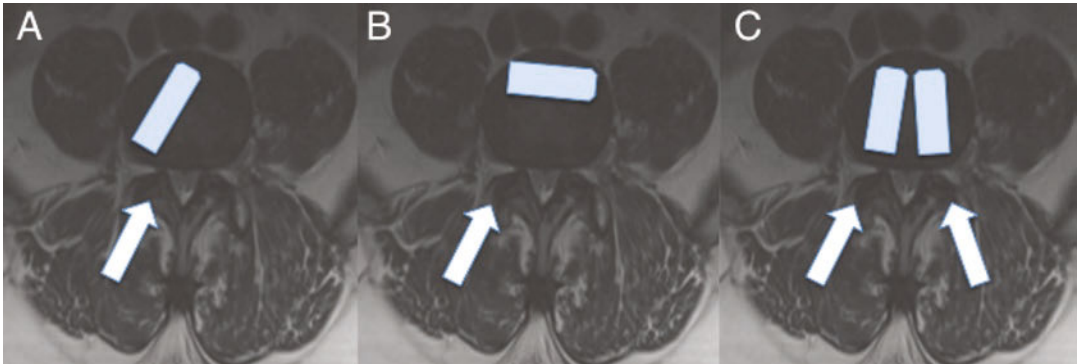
Techniques for graft placement during TLIF. An axial T2-weighted MR at the L4–L5 disc space demonstrating different approaches for placement of intervertebral cages when performing a TLIF. Straight cages may be placed in a diagonal fashion across the disc space to maximize disc space height restoration (a). Alternatively
